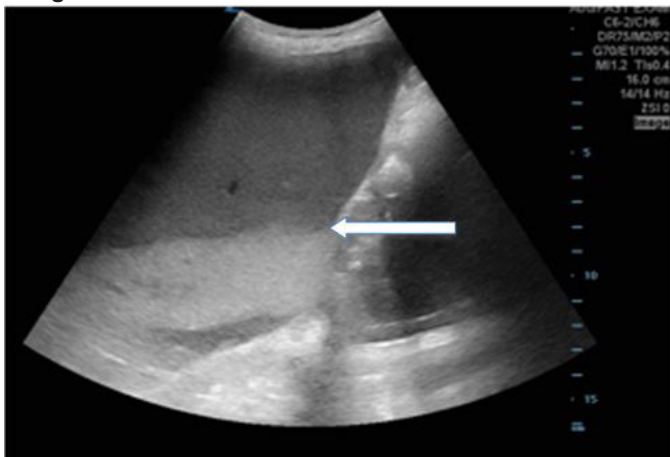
Image 2ab. a) Point-of-care ultrasound (POCUS) with dilated stomach and surrounding intraperitoneal free fluid (blue arrow); b) POCUS with "black-and-white cookie" sign seen by white arrow with division of stomach contents.
